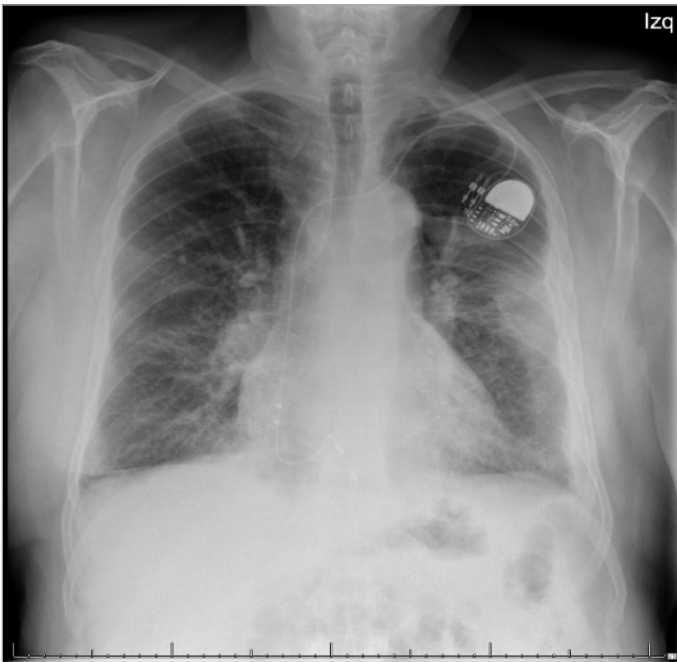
Chest x-ray corresponding to admission. Postero-anterior view. It showed data of water overload and bilateral opacities probably related to pneumonic foci.
